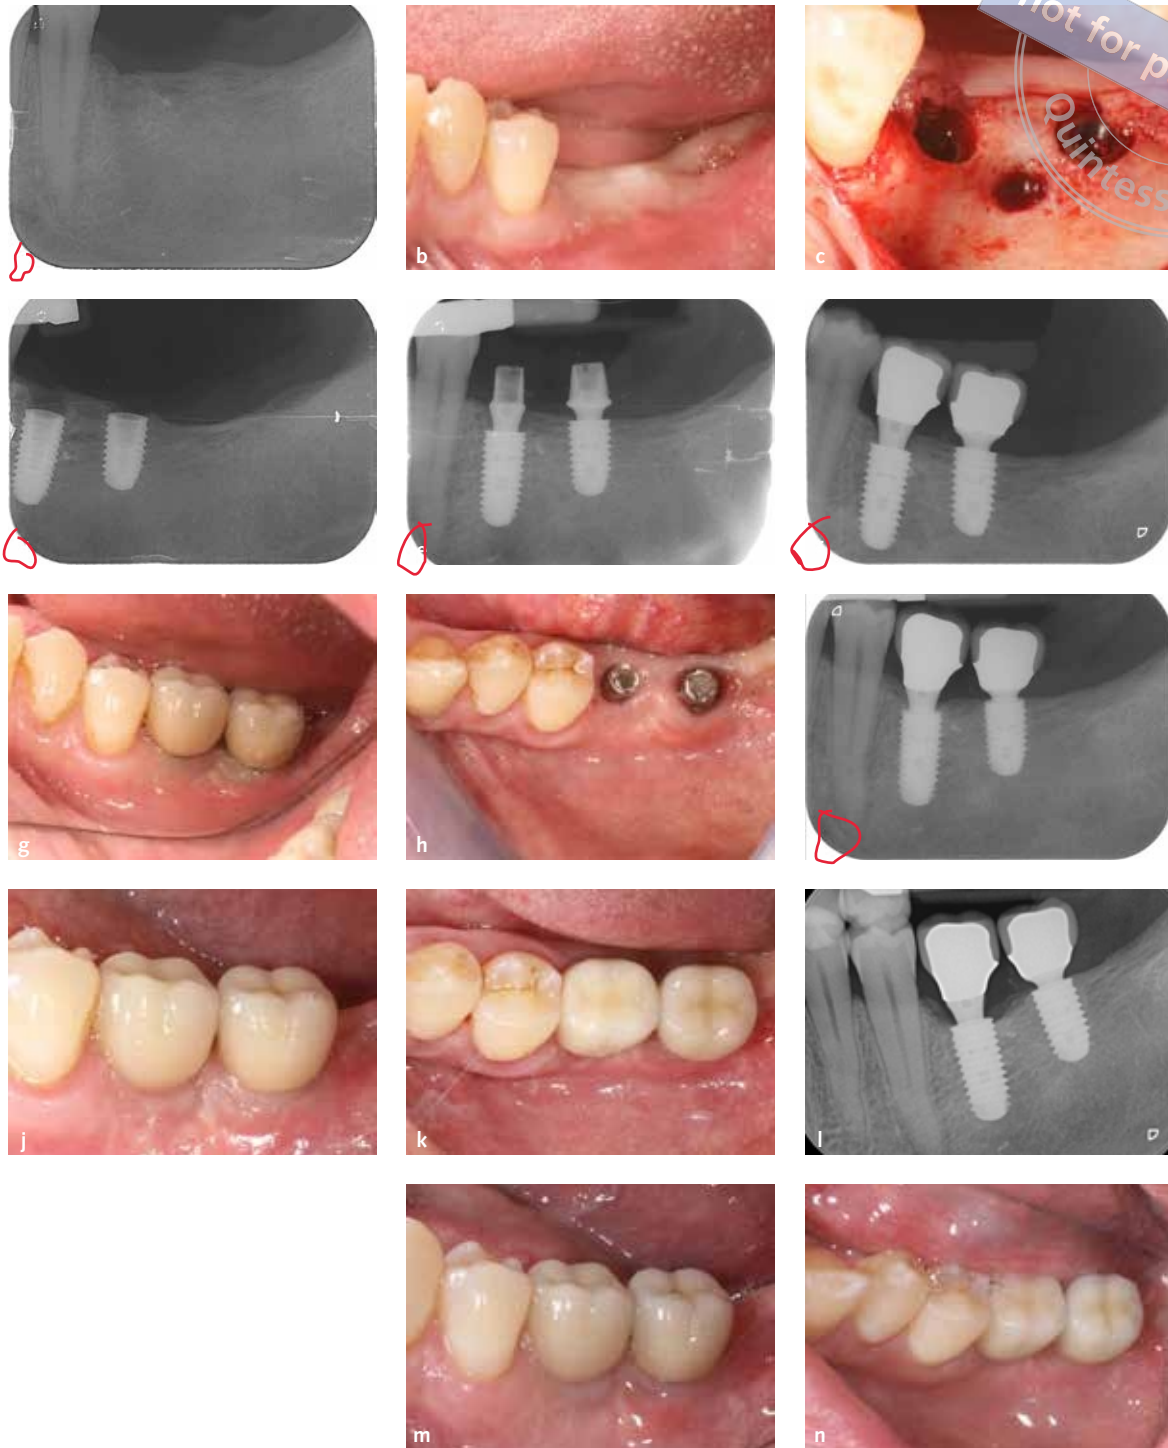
Treatment sequence of a representative patient treated by Dr Salina: (a) pre-operative periapical radiograph and (b) clinical view; (c) site 36 was randomly allocated to receive an implant with the neck 1.5 mm below the crest and site 37 at 0.5 mm below; (d) postoperative baseline periapical radiograph clearly showing the difference in depth positioning; (e) periapical radiograph at initial loading; (f) periapical radiograph at delivery of definitive crown 2 months after initial loading; (g) vestibular and (h) occlusal view (without the definitive crowns) at delivery of definitive crown; (i) periapical radiograph, (j) vestibular, and (k) occlusal view at 1 year after loading; (l) periapical radiograph, (m) vestibular, and (n) occlusal view at 3 years after loading.
